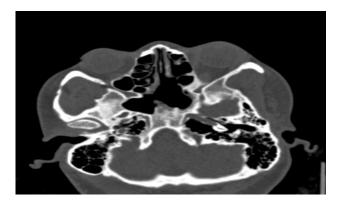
Post-operative axial CT-scan after radical sphenoidectomy showing resolution of the left sphenoid sinusitis with resolution of bone thickening.
